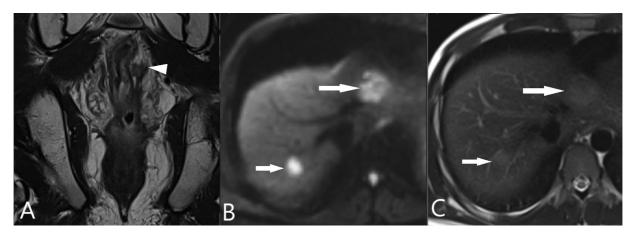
Progression after total neoadjuvant therapy (TNT) with new liver metastases. (A) Coronal T2 high-resolution (HR) magnetic resonance imaging (MRI) shows persistent tumor signal extramural vascular invasion (EMVI) and tumor deposit (TD) (arrowhead). (B) Diffusion-weighted imaging (DWI) (b800) shows liver metastases (arrows). (C) T2 large field of view (FOV) axial MRI of the liver showing faintly visible mildly hyperintense liver metastases (arrows).
